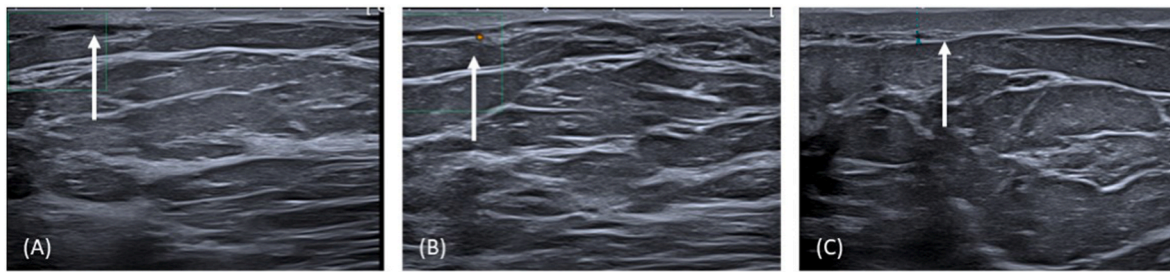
Ultrasound Images. Focused ultrasound scan of reddened area in left lateral breast and region superior. There was skin thickening measuring 3.8 mm at the site of the red skin in the left lateral breast at 3–4 o'clock (C). No underlying collection was present. Slightly superior at 2–3 o'clock at the site of ridge-like lumpiness, there was an elongated blood vessel lying below the dermis, which was not completely compressible and does not demonstrate colour flow on doppler (A + B). Appearances are in keeping with thrombosis and a diagnosis of Mondor's disease of the breast.
